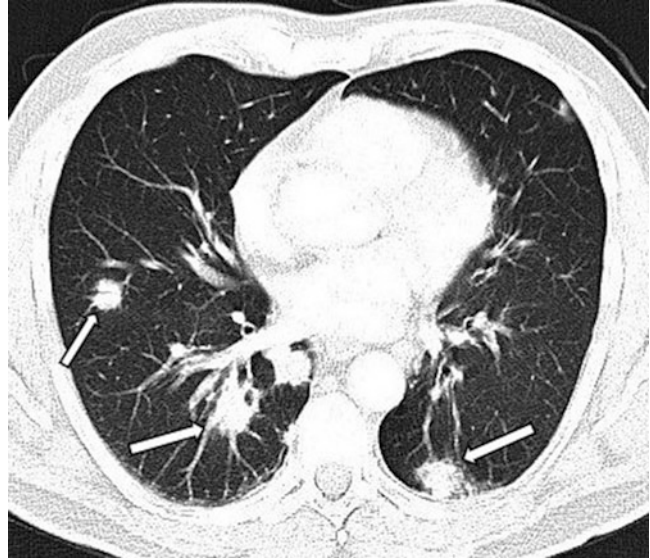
Computed tomography (CT) scan of the chest showing nodular shadows in lung parenchyma (marked by arrows)
